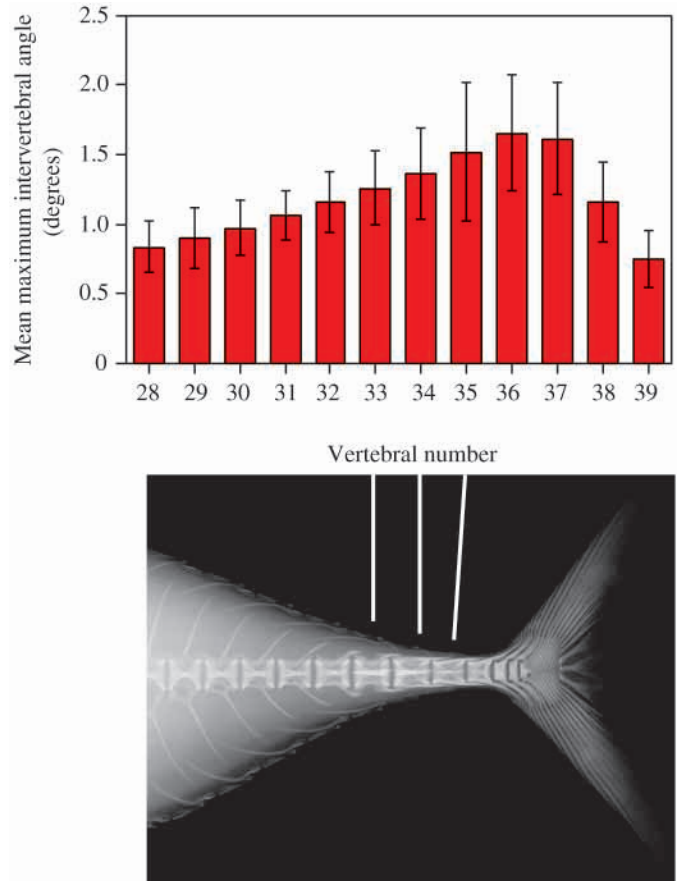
Mean maximum intervertebral bending angles for the intervertebral joints anterior to vertebrae 28–39, the last vertebra, in the kawakawa and an X-ray of the caudal region (lateral view) of a 260 mm fork length kawakawa. The bony lateral keel is on vertebrae 33, 34 and 35, indicated by the lines. Values are means  $\pm$  S.D. ( $N=3$ ).
